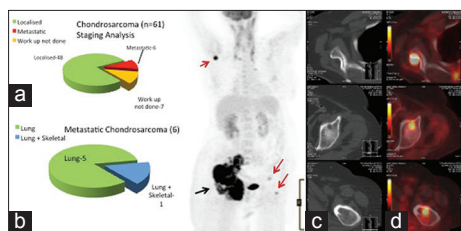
(a) Staging analysis of all chondrosarcomas seen over a period of 1 year. (b) Site distribution of metastatic chondrosarcomas. (c) Whole body positron emission tomography – computed tomography showing the site of primary lesion in right hemipelvis (black arrow) and distant skeletal metastasis in right glenoid, left acetabulum and greater trochanter of left femur (red arrows). (d) Positron emission tomography images showing intense fluorodeoxyglucose avid lesions at skeletal metastatic sites
